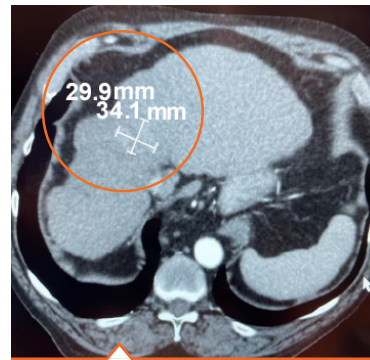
Pre-treatment CT shows a 30x34mm HCC lesion in Segment 4/8.
